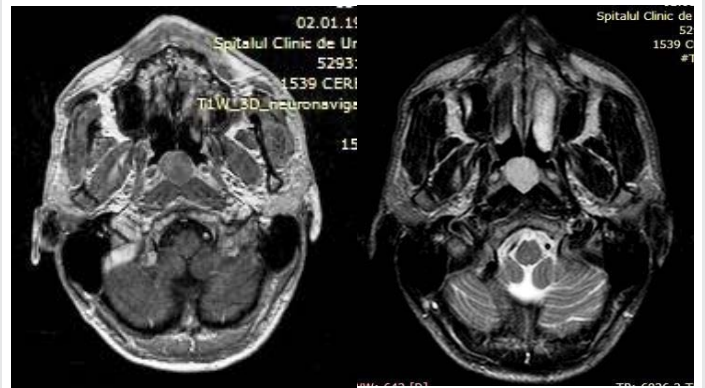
MRI in T1 and T2.
